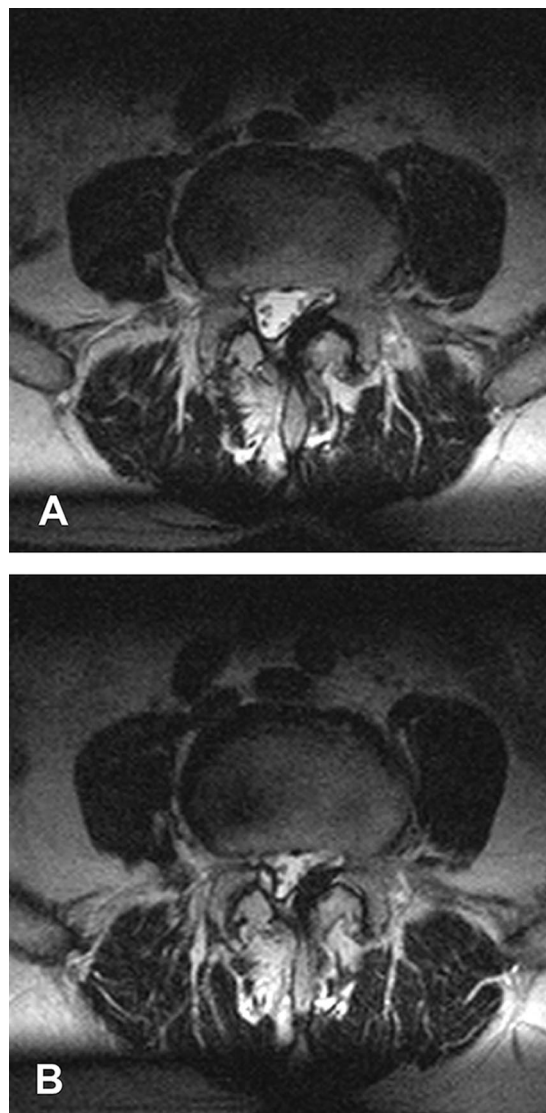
Patient MR25 (Tables 1 and 2). A 79-year-old man with a right L5 rhizopathy. Traditional MRI did not show any significant narrowing explaining his complaints (A) (L4–L5 level). Axial loaded MRI showed a synovial cyst compressing the L5 nerve root at the L4–L5 level (B). Surgery with removal of the medial part of the L4–L5 joint and the synovial cyst was performed. One year after surgery, he was much improved regarding his leg pain and he could walk 500 to 1000 m.
